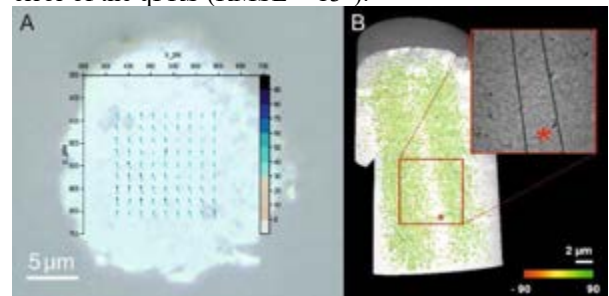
A: qPRS map collected atop the interstitial bone with marked MCF orientations; B: nano-CT scan with MCF segmentation of osteonal bone volume with the distinct interlamellar region (*) (adapted from [2]).
